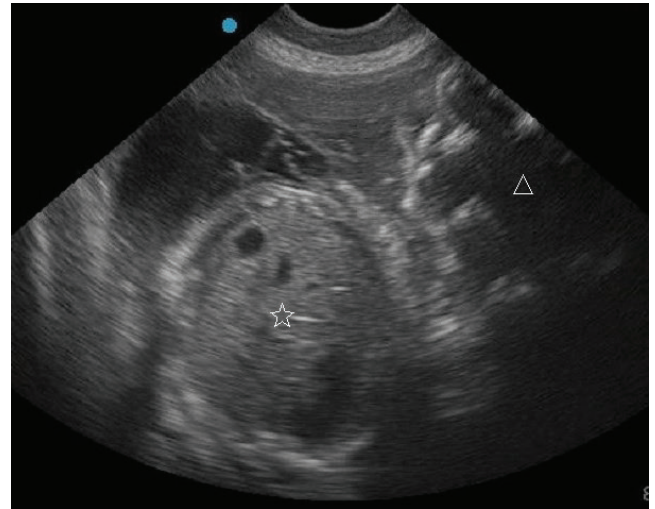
Transabdominal ultrasonographic image of live (star) and autolyzed (triangle) fetuses.
